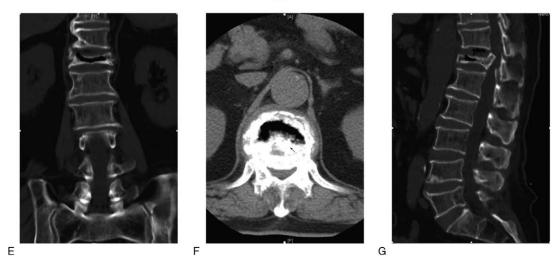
An 81-year-old male with a compression fracture at the T12 vertebral body due to trauma: anteroposterior x-ray film (a) and lateral x-ray film (b) revealed apparent deformities at the T12 vertebral body, anterior vertebral compression rate was approximately 60%, and the intraosseous vacuum phenomenon was observed. MRI T2-weighted image (c) and MRI STIR fat-suppressed image (d) revealed a hyperintense signal in T12; coronal CT scan (e), axial CT scan through T12 (f), and sagittal CT scan (g). This was confirmed intraosseous vacuum phenomenon, and bone sclerosis was observed around the vacuum sites. CT = computed tomography, MRI = magnetic resonance imaging, STIR = short tau inversion recovery.
